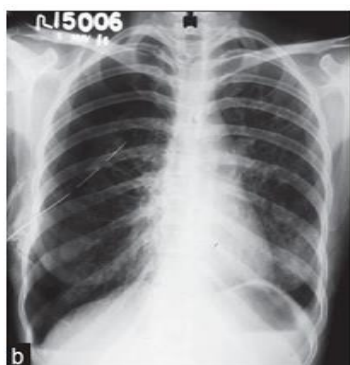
Plain radiograph chest showing right side intercostal drainage tube in situ
